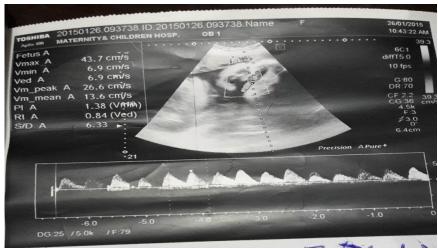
shows reduced end diastolic Color Doppler of the umbilical artery waveform at 32 Wks .
